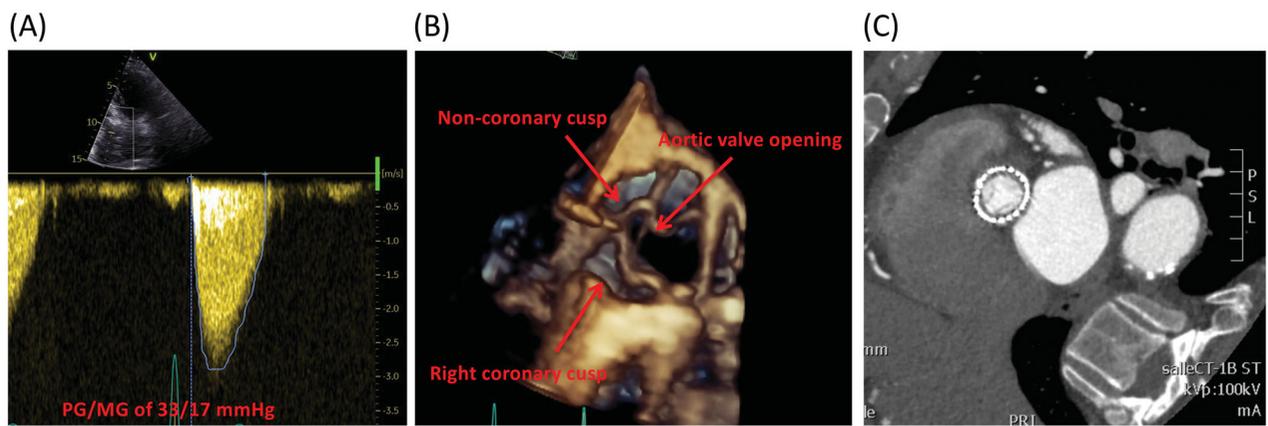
2D/3D echocardiography and cardiac scanner of the aortic valve after antioagulation treatment.
